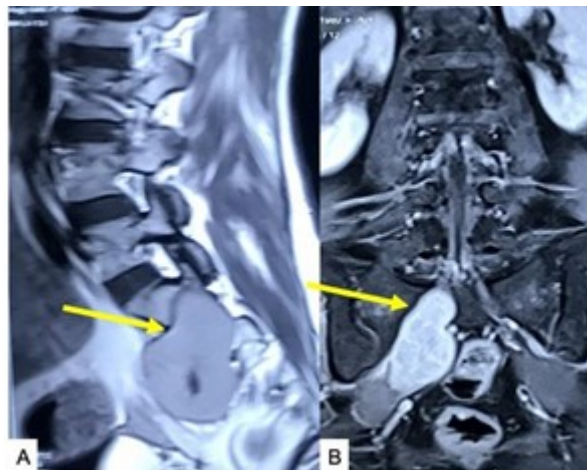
MRI of lumbosacral spine (A) T1W sagittal image and (B) contrast coronal image showing right S2 schwannoma (arrow marked) extending into pelvis (posterior to rectum). Source: Figure by authors.
